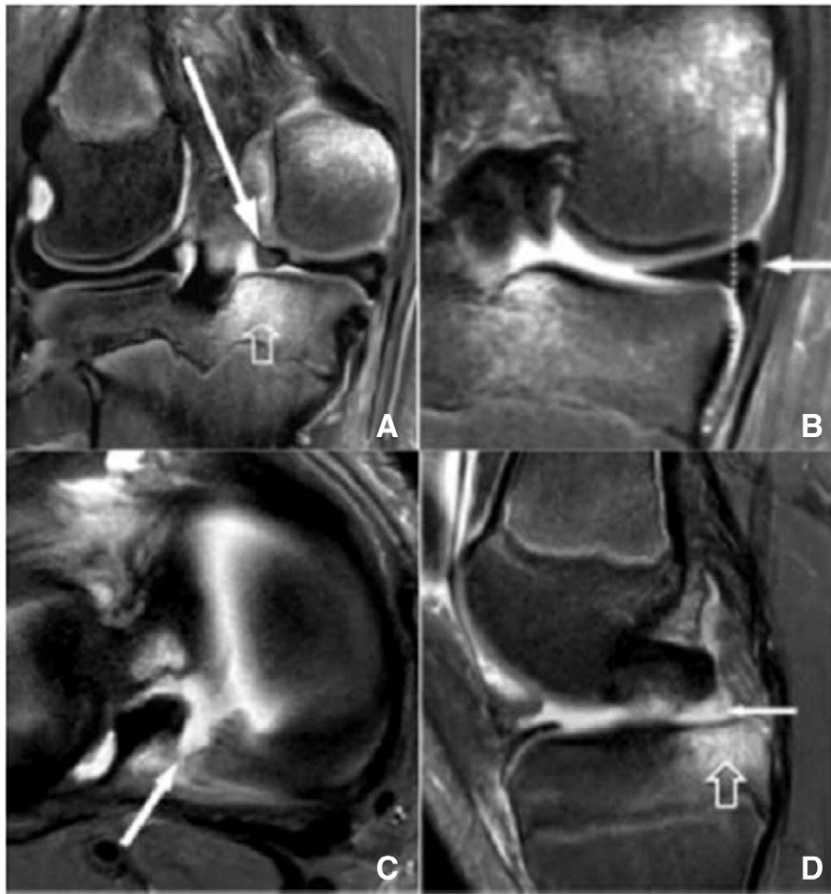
Preoperative MR imaging of patient 1; T2 weighted images with fat suppression. (A) Coronal view. Bone bruise oedema (open arrow) and truncated aspect of the posterior horn of the medial meniscus filled with fluid T2 hypersignal intensity. Note retraction of the avulsed root of the medial meniscus (solid arrow). (B) Coronal slice at the level of the MCL demonstrating minor meniscus extrusion (solid arrow) indicative of the root avulsion. (C) Axial view. T2 hypersignal intensity and complete defect of the medial meniscal posterior root attachment (solid arrow). (D) Sagittal view, postero-medial tibial bone bruise oedema (open arrow) and a complete defect of the posterior meniscal root filled with fluid T2.
